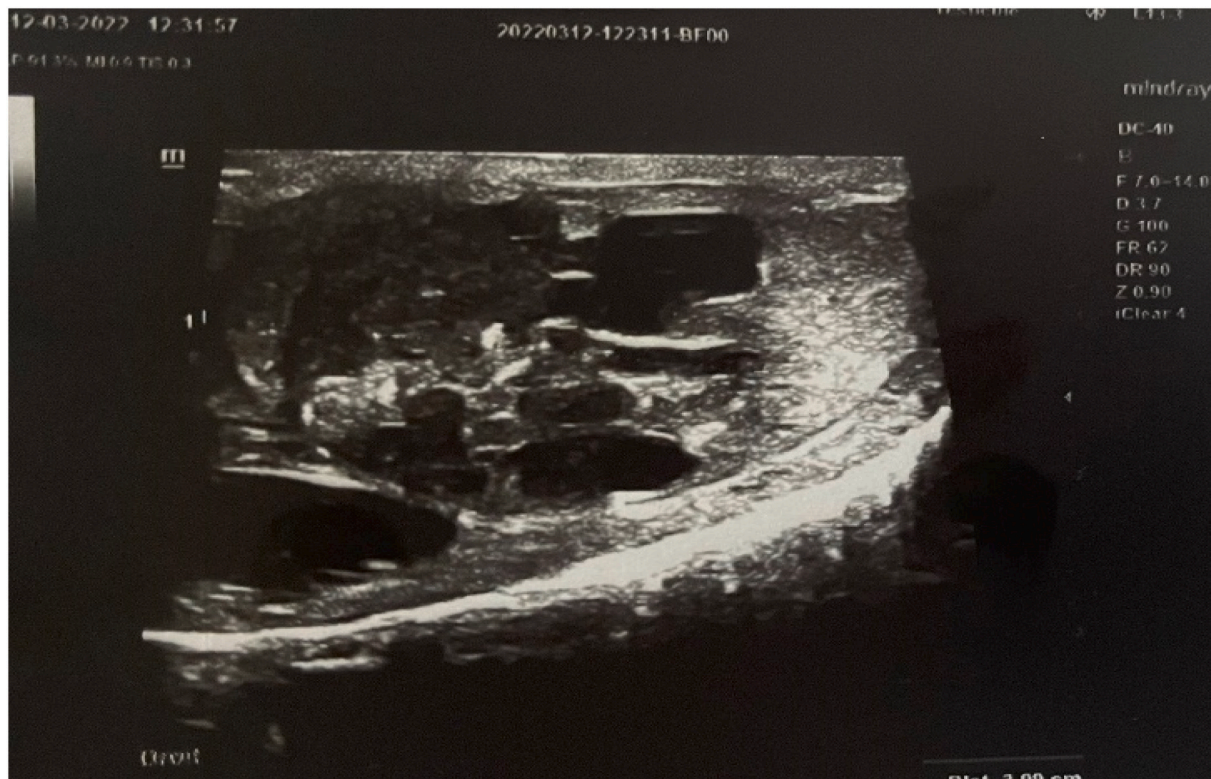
Representative ultrasound images of the testicular mass.
